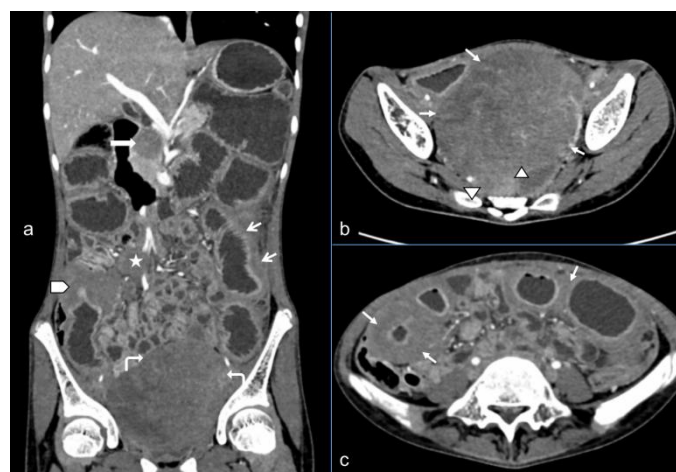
Coronal and axial images of CECT scan. *Fig. 1a- Coronal reformatted images of contrast enhanced CT scan of abdomen showing a large solid mass in the pelvis (curved arrows); multi-focal small bowel wall thickening (thin arrows and arrowhead); mesenteric lymph node (star) and hypo-enhancing solid lesion in pancreas (thick arrow).*
